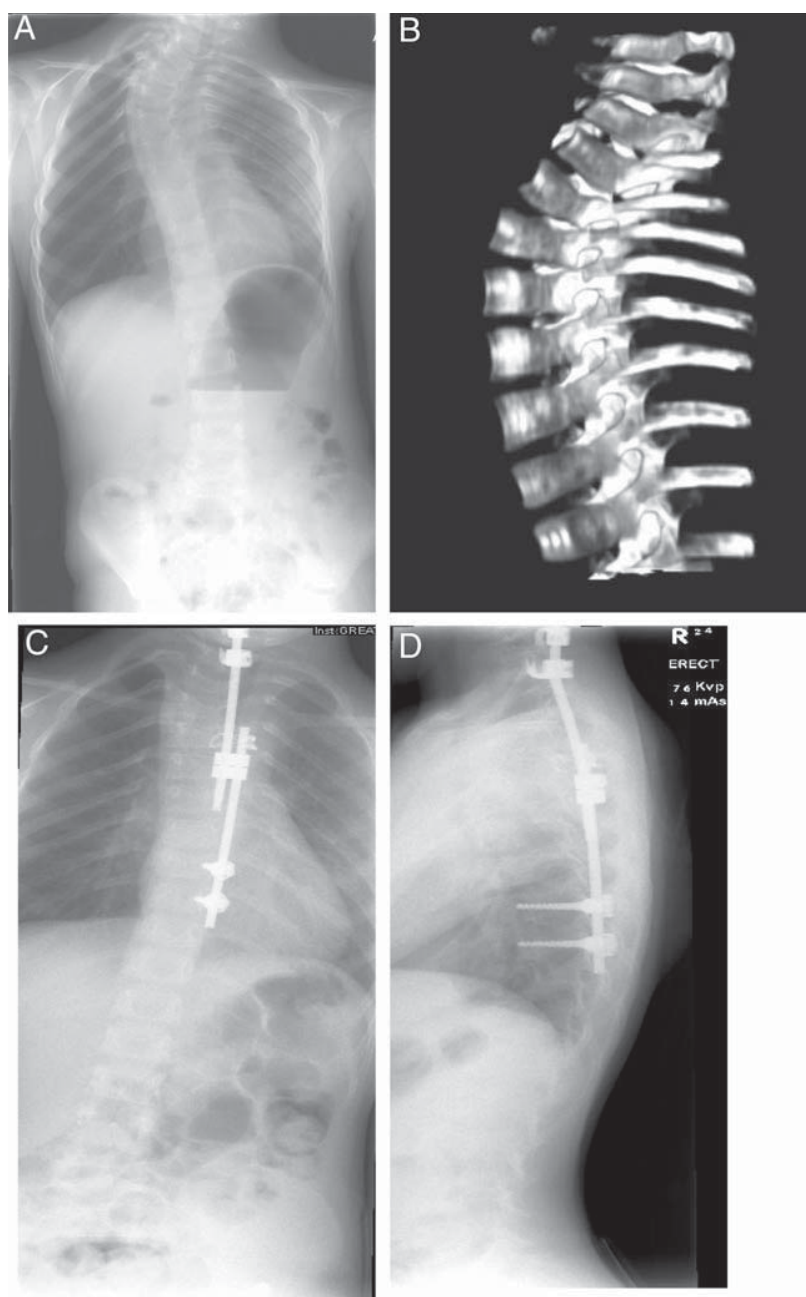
Preoperative AP radiograph (A) and sagittal CT (B) of case 1 demonstrating severe upper thoracic lordosis. Postoperative AP (C) and lateral (D) radiographs the correction achieved using submuscular growing rods.
